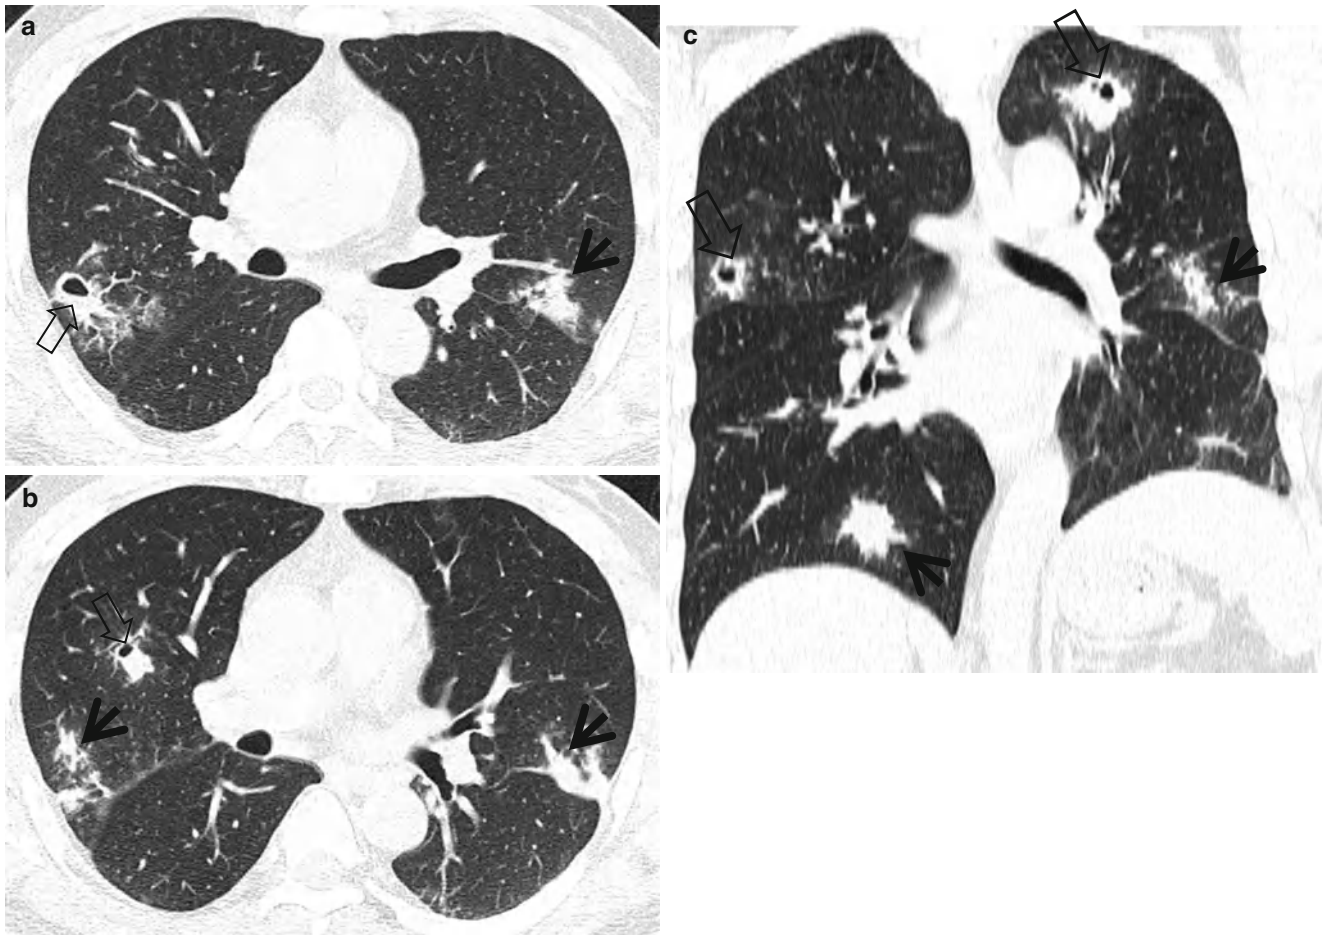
Pulmonary *Paragonimus westermani* (PW) infestation in a 46-year-old man proved by sputum smear showing parasitic eggs and positive ELISA test for PW. (a, b) Lung window images of consecutive CT (2.5-mm section thickness) scans obtained at levels of right
